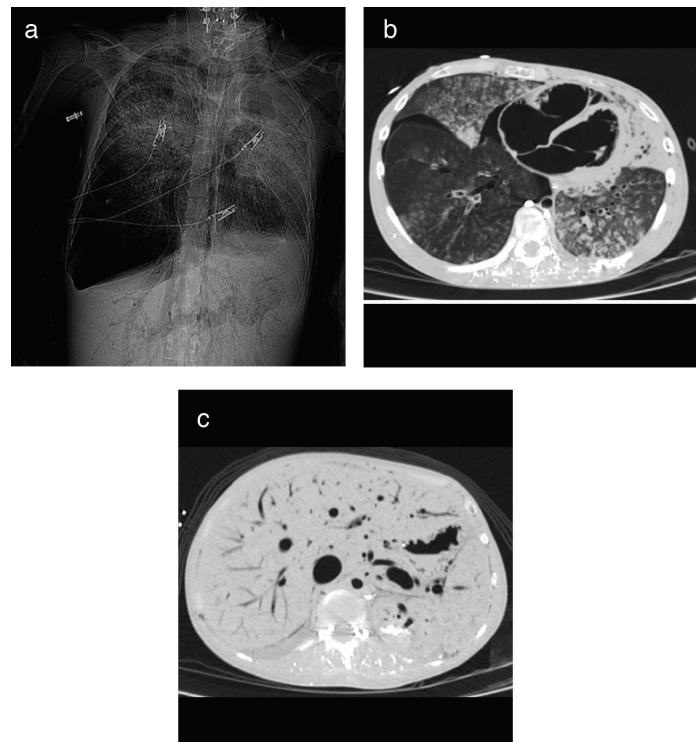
CT scanogram (a) and axial images on chest CTA show that the four chambers of the heart (b), arterial and venous vascular systems, including the portal venous system (c), are completely filled with air.
